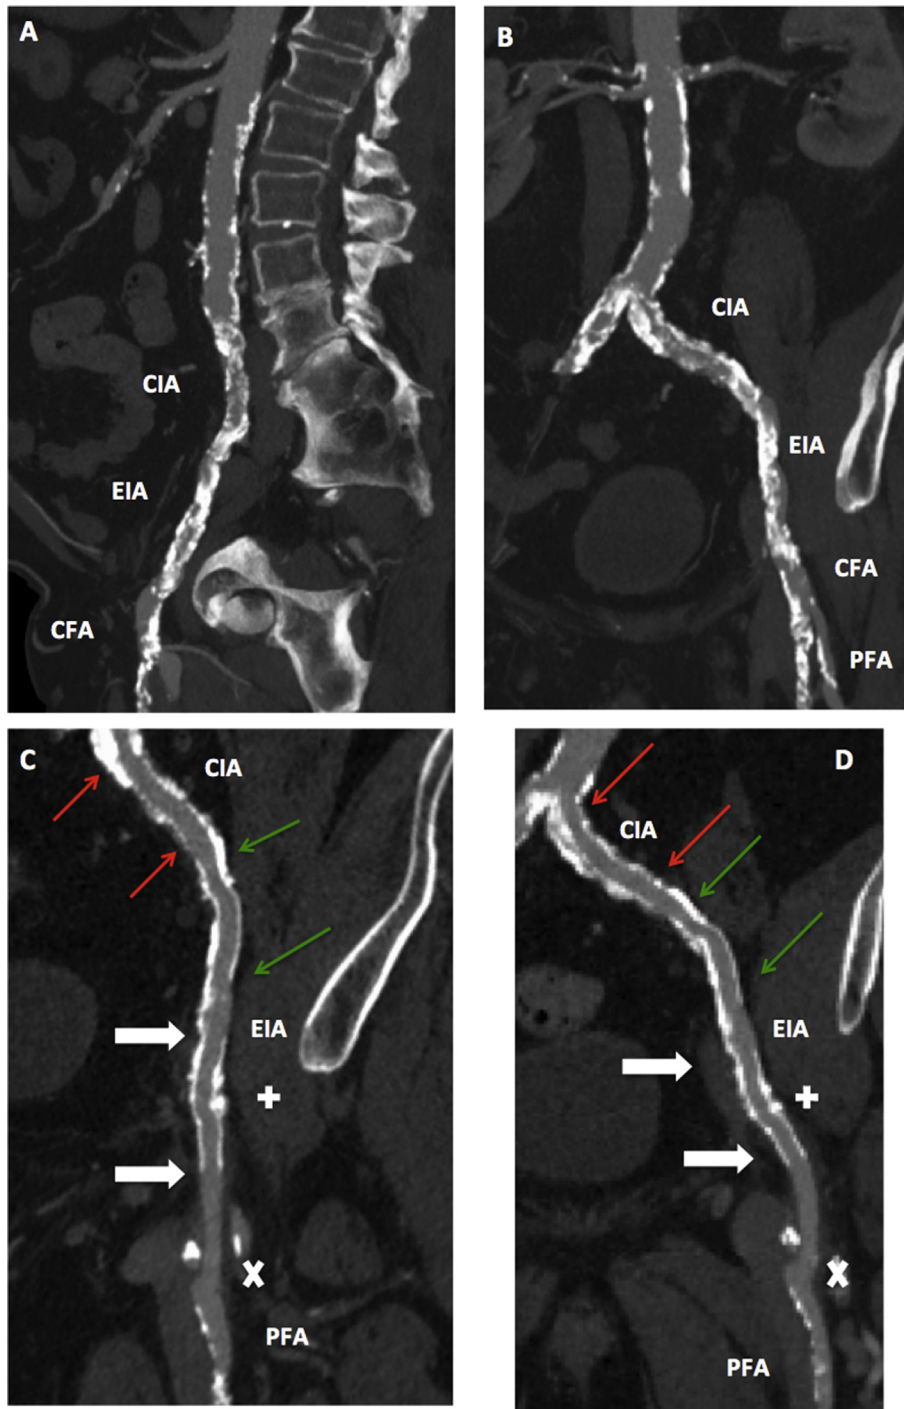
Computed tomography (CT) scans of patient 1. (A) Pre-operative CT scan with sagittal reconstruction of the left aorto-ilio-femoral arterial axis. (B) Pre-operative CT scan with reconstruction of the left aorto-ilio-femoral arterial axis. (C, D) Post-operative CT scan at 1 month in the same patient with reconstruction of the left aorto-ilio-femoral arterial axis. Arrows (→) indicate the position of the covered VIABAHN stent to perform the VIABAHN Open Revascularisation TEChnique (VORTEC). The iliofemoral bypass is represented between (+) and (×). (+) Localises the proximal anastomosis using VORTEC and (×) indicates the regular distal anastomosis on the profunda femoral artery. In this case, extensive stenting of the external iliac artery (EIA) with a nitinol covered stent (→) and stenting of the common iliac artery (CIA) with a bare metal stent (→) completed the iliofemoral bypass. *Note.* CFA = common femoral artery; PFA = profunda femoral artery.
